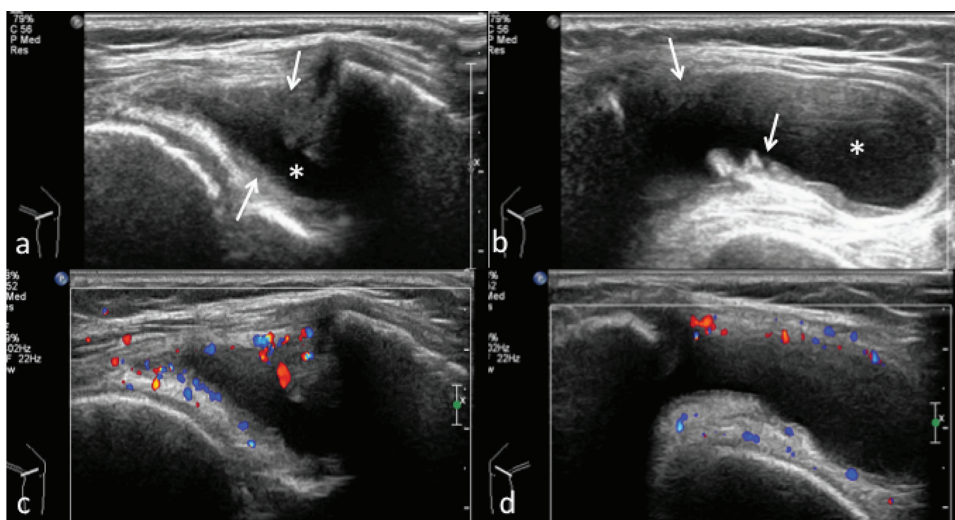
Oligoarthritis-type JIA in a 9-year-old girl with a 2-week history of left knee pain and swelling. Transverse US images of left knee at the medial recess (a) and lateral recess (b) show thickening of hyperechoic synovial tissue (arrows) and large amount of hypoechoic joint effusion (*). (c, d) Color Doppler images show moderate-degree synovial hyperemia. The symptoms responded to intra-articular steroid and medical therapy.
